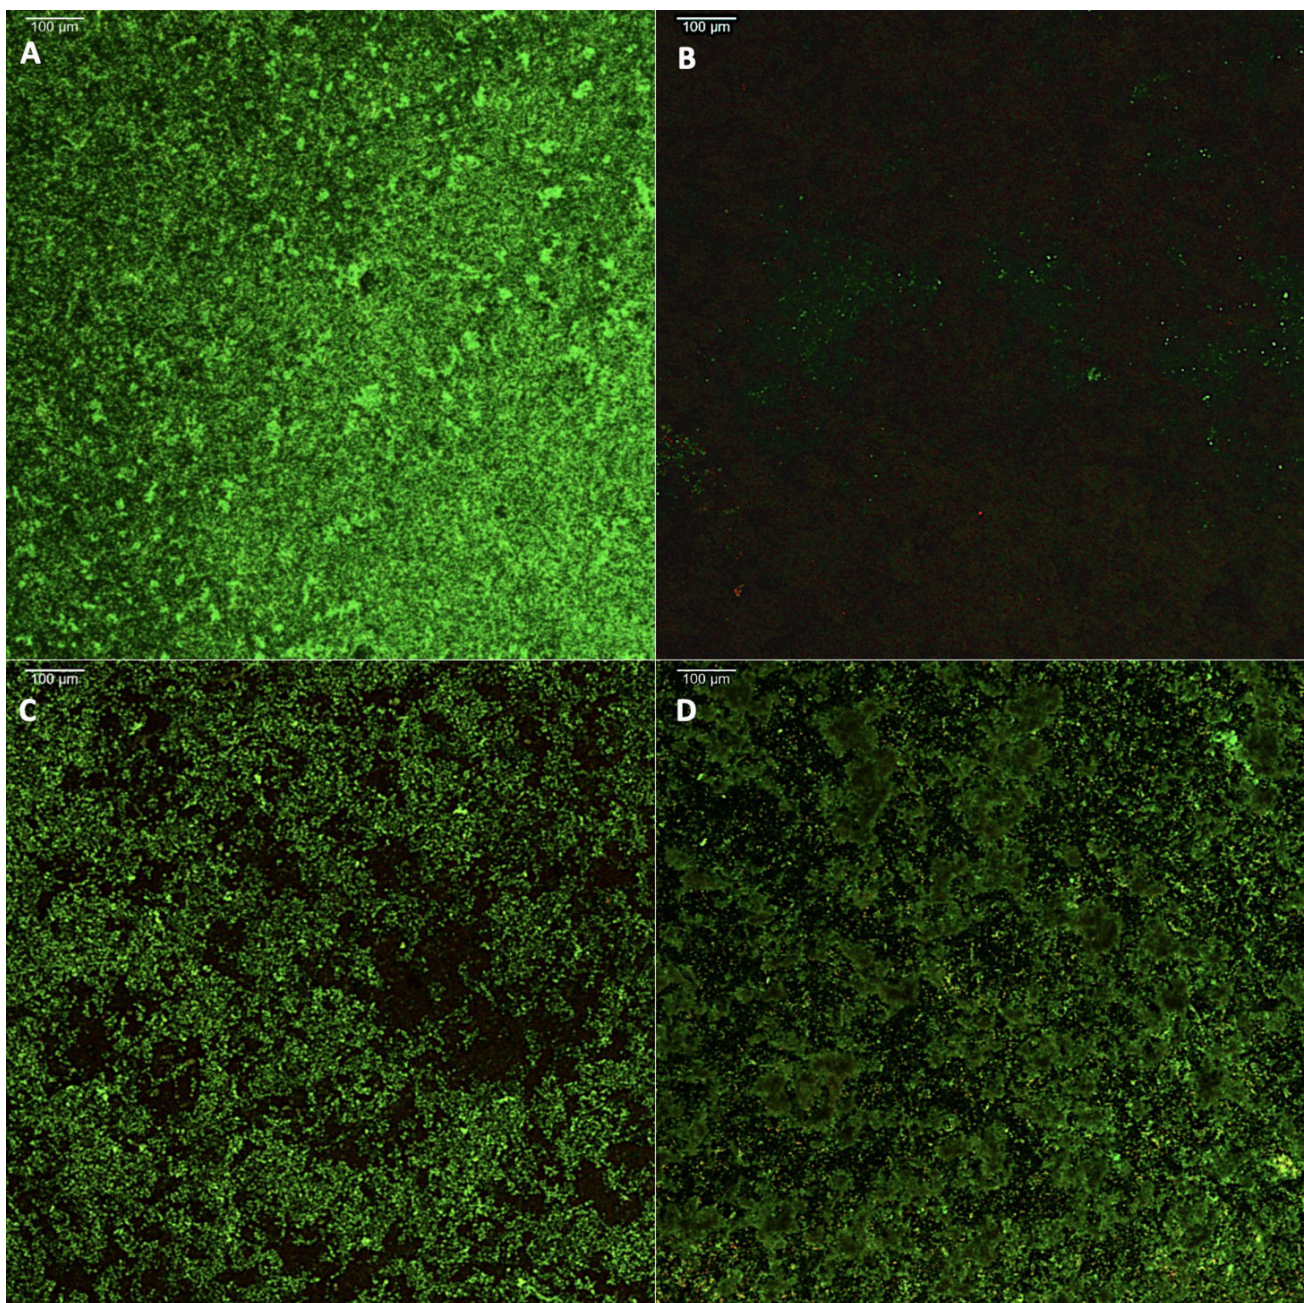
Representative CSLM images of *S. aureus* biofilm on the surfaces of control and treatment discs: (A) Control, (B) Ultrasonic-driven steel tip, (C) Ultrasonic-driven plastic tip, (D) Plastic curette (Viable bacteria = green; dead bacteria = red).
